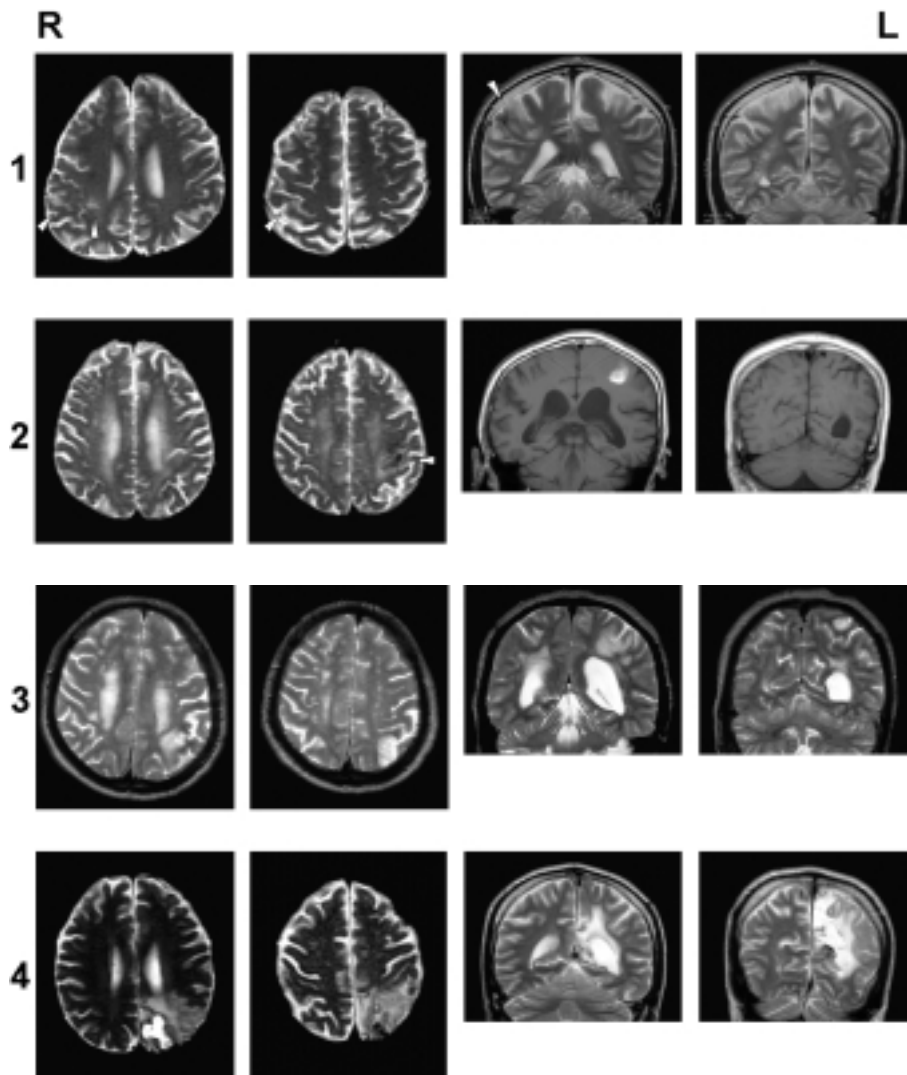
MRI axial and coronal images of patients 1 to 4. Number corresponds to the patient number. Axial slices are at the level of upper part of the lateral ventricle and the intraparietal sulcus, and coronal slices area at the level of the posterior horn of the lateral ventricle and the angular gyrus. 2-1: High intensity areas were noted in the right postcentral gyrus posterolateral to the precentral knob, cortico-subcortical structures in the supramarginal gyrus on T2-weighted images (arrowhead, Time of repetition [TR] / Time of echo [TE] = 7999msec/104msec). These lesions were identified with diffusion-weighted images. On the coronal view, the postcentral gyrus lesion extended deep to the lateral ventricle (TR/TE = 4000/83). 2-2: A low intensity area suggestive of hemorrhage was localized in the left postcentral gyrus posterior to the precentral knob on T2-weighted images (arrowhead, TR/TE = 7999/101). On the T1-weighted planes, a high-intensity hemorrhage was noted over the posterior horn of the lateral ventricle (TR/TE = 500/14). 2-3: A high intensity area posterior to the postcentral sulcus extended deep along the intraparietal sulcus to the lateral ventricle on T2-weighted axial images (TR/TE = 3500/96). 2-4: A thin high intensity area was located in the occipital and parietal lobes that extended anteriorly to the postcentral sulcus, surrounding an old infarction (thick intensity area) in the medial occipital lobe on T2-weighted axial images (TR/TE = 7999/101). The new lesion involved the superior parietal lobule, angular gyrus and precuneus that extended posteriorly to the superior occipital gyrus on coronal images (TR/TE = 4000/84).
